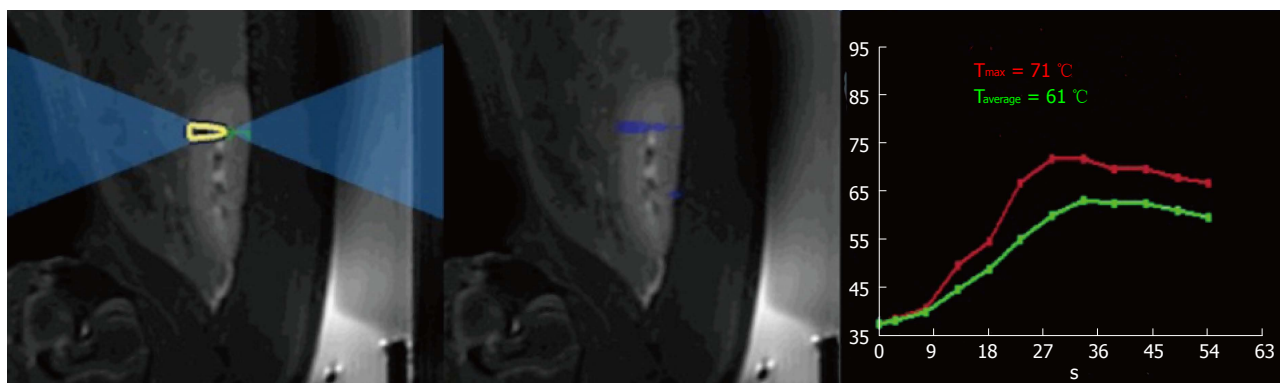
A localizer was performed to verify the position of the kidneys relative to the transducer. Coronal T2-weighted (T2-W) magnetic resonance images show the result of added T2-W treatment planning sequence, which was transferred to the high intensity focused ultrasound software (left and center). The right plot shows the temperature rise during ablation in the renal parenchyma. The red temperature curve represents the maximum temperature measured at the point of focus, while the green curve represents the average temperature in the region of interest.
